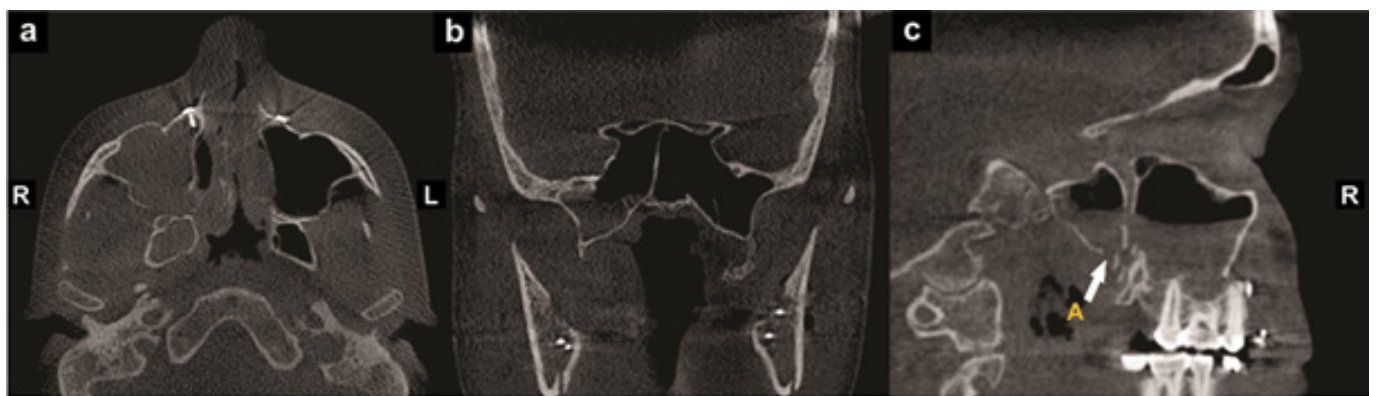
Postoperative CBCT exam for orthognathic surgery, showing the SS'opacification on the right side in multiplanar (a) axial, (b) coronal and (c) sagittal reconstructions. The fracture in the floor of the SS is observed in sagittal reconstruction (c-A).
